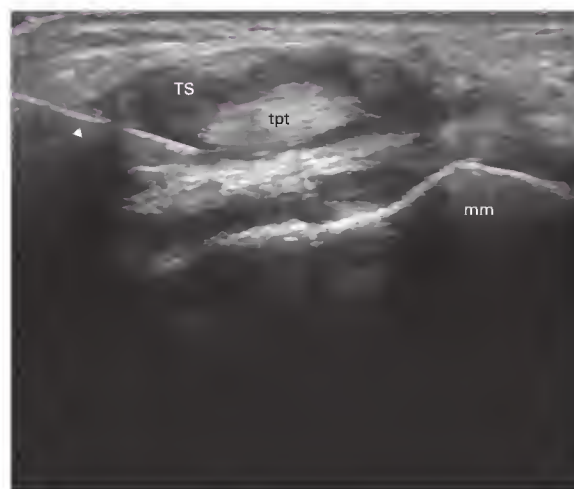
Ultrasound-guided direct injection for tenosynovitis of the tibialis posterior tendon. The needle (arrowhead) is inserted within the distended tendon sheath (TS). mm, medial malleolus; tpt, tibialis posterior tendon.
